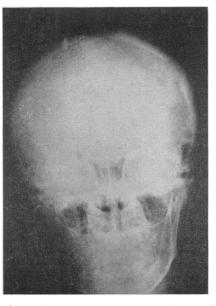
Radiograph showing pagetoid lesions of calvarium and multilocular cyst of right mandible
